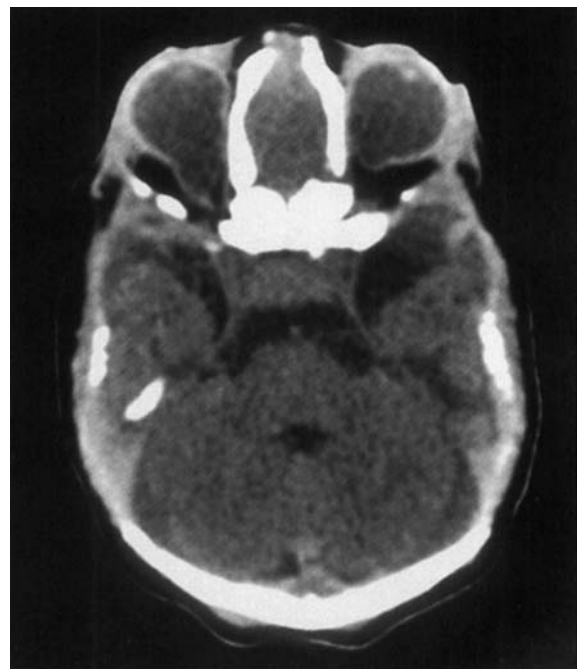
Axial computed tomogram, at level of eyes, demonstrates bilateral uveal colobomas and severe proptosis.
